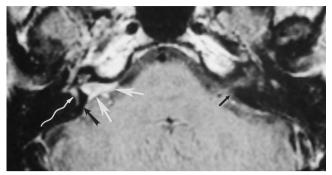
Masslike pattern of enhancement within the IAC; retrosigmoid craniotomy. Axial contrast-enhanced T1-weighted image (650/23/2) shows enhancing tissue filling the IAC (*straight white arrows*). The vestibule (*wavy arrow*) and the cochlea (unlabeled) were hyperintense before contrast administration, so it is not possible to determine on this image whether there is also enhancement. The posterior lip of the porus acusticus had been drilled away (*large black arrow*) as part of the retrosigmoid craniotomy. The left porus (*small black arrow*) is normal.
